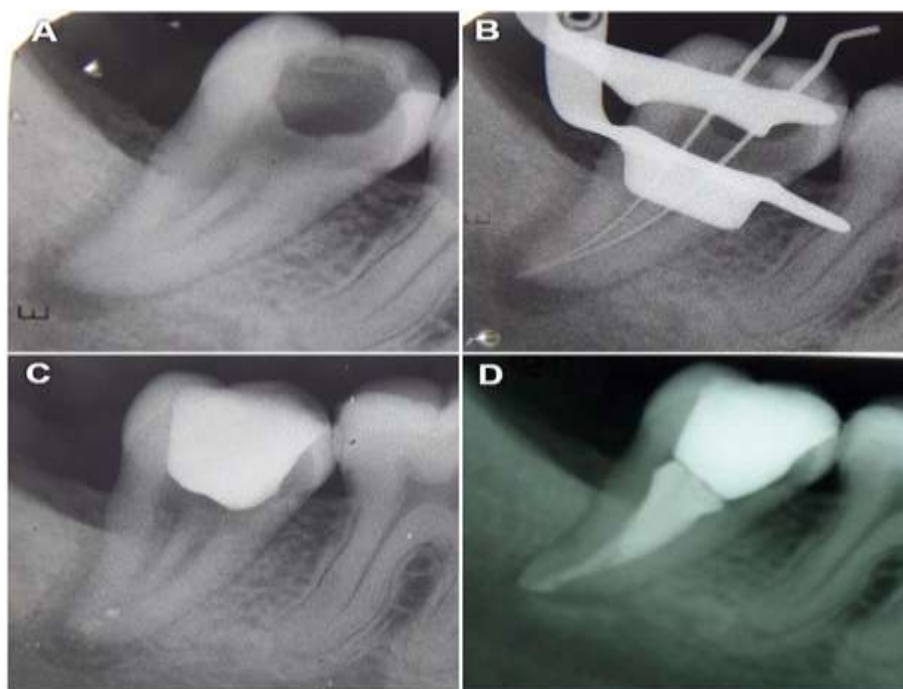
(A) Preoperative radiograph; (B) Working length radiograph; (C) Follow-up radiograph; (D) Obturation radiograph
